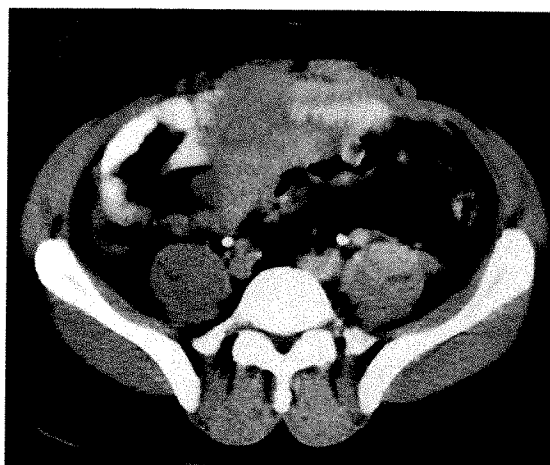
Bowel and mesenteric injury. CT scan shows hyperdense mass surrounding ileal loops and extending into mesentery. Bowel-wall thickening and free hemoperitoneum were present on other sections. Surgery confirmed laceration of terminal ileum and a mesenteric hematoma.
